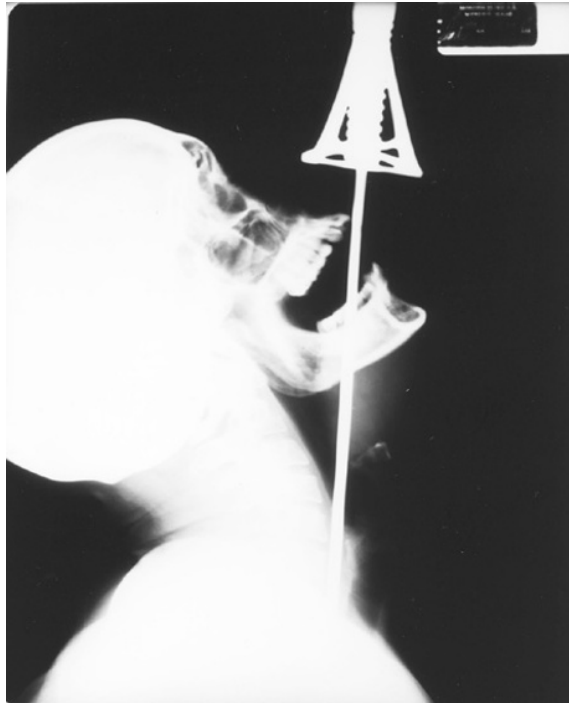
Radiograph of Mr. Brad Byers “swallowing” a sword. Courtesy of Brad Byers (<http://www.bradbyers.com/>).
